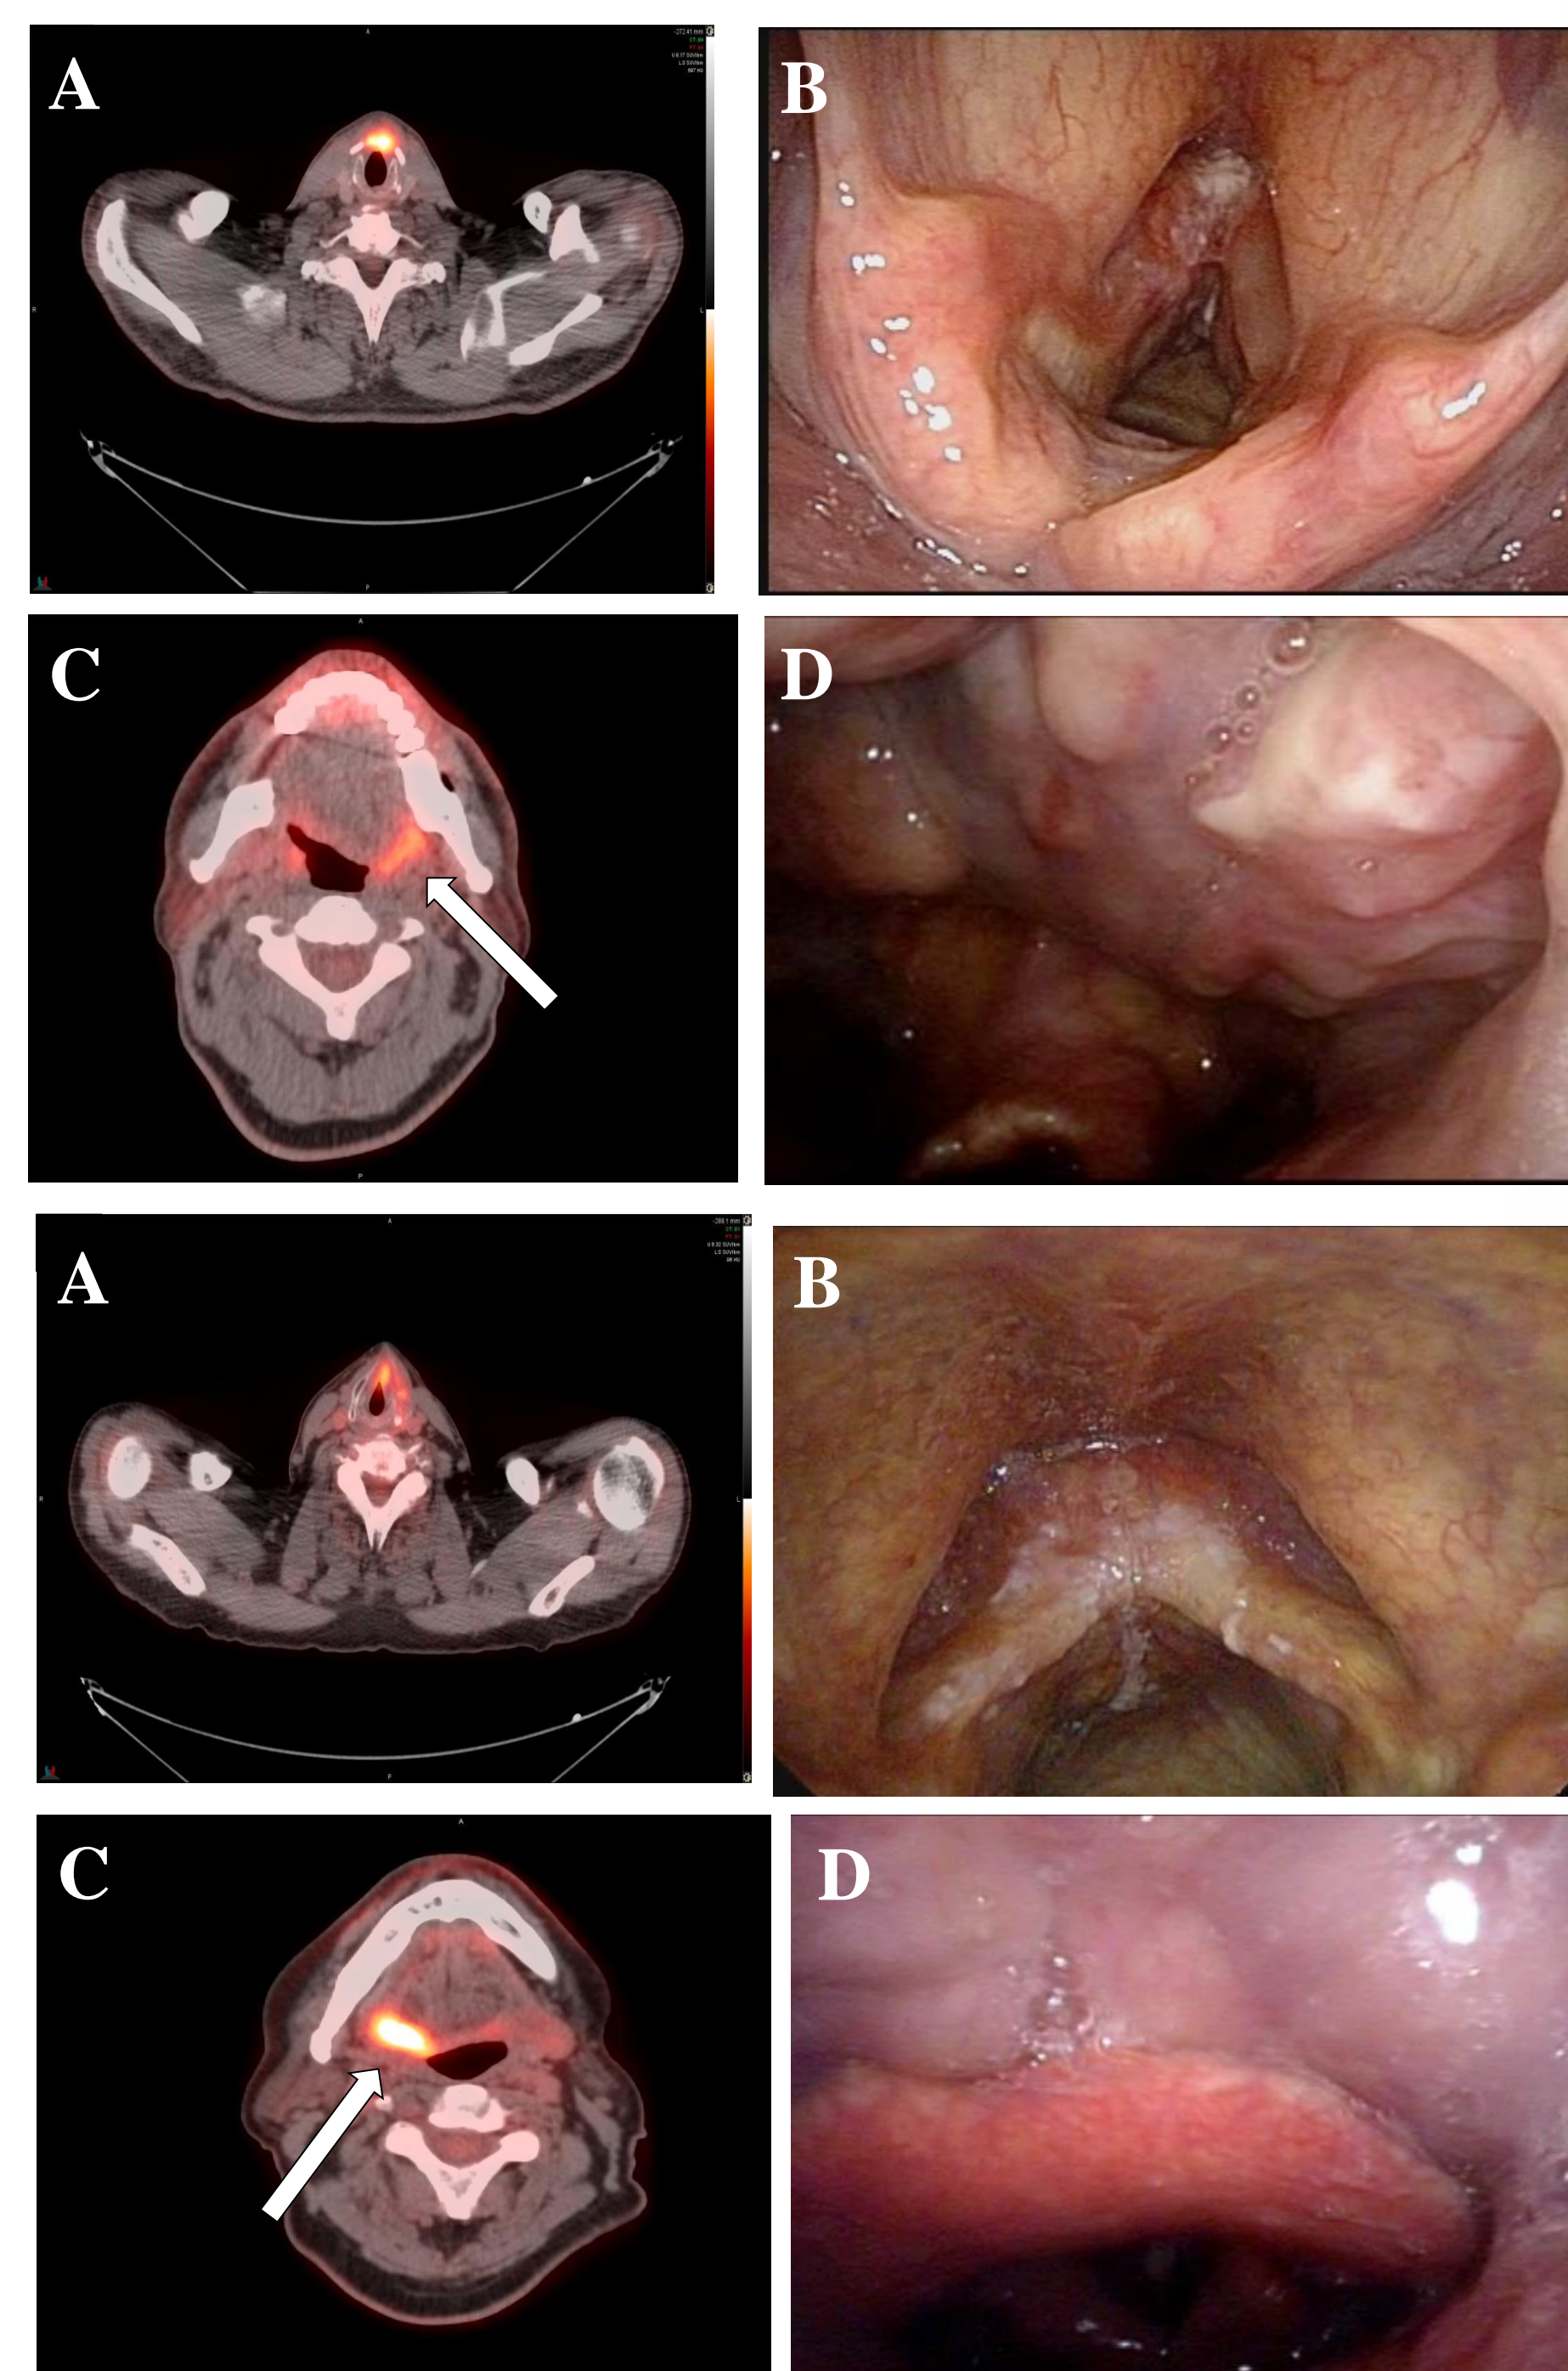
(A) FDG uptake in the primary tumor location. (B) Laryngoscopic image of glottis. (C) False positive FDG uptake in base of tongue. (D) Laryngoscopic image of normal base of tongue.
